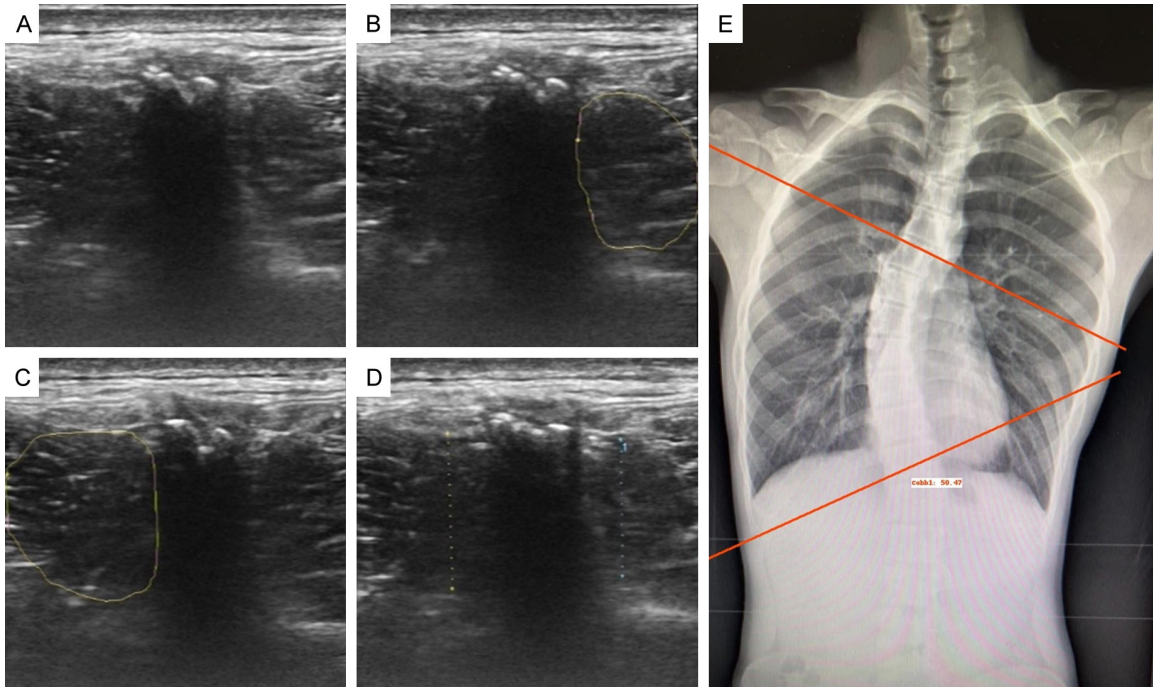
Ultrasound measurements at the apex vertebra in AIS patients. The apex vertebra was defined as the vertebra with the greatest lateral deviation of the main scoliotic curve on standing full-spine radiographs. A. Cross-sectional two-dimensional ultrasound image of the paravertebral muscles at the apex vertebra in a patient with AIS. B. Measurement of circumference and area on the convex side at the apex vertebra. C. Measurement of circumference and area on the concave side at the apex vertebra. D. Measurement of anteroposterior diameter of the paravertebral muscles at the apex vertebra. E. Standing full-spine radiograph showing right convex scoliosis with a Cobb angle of 50.47°.
